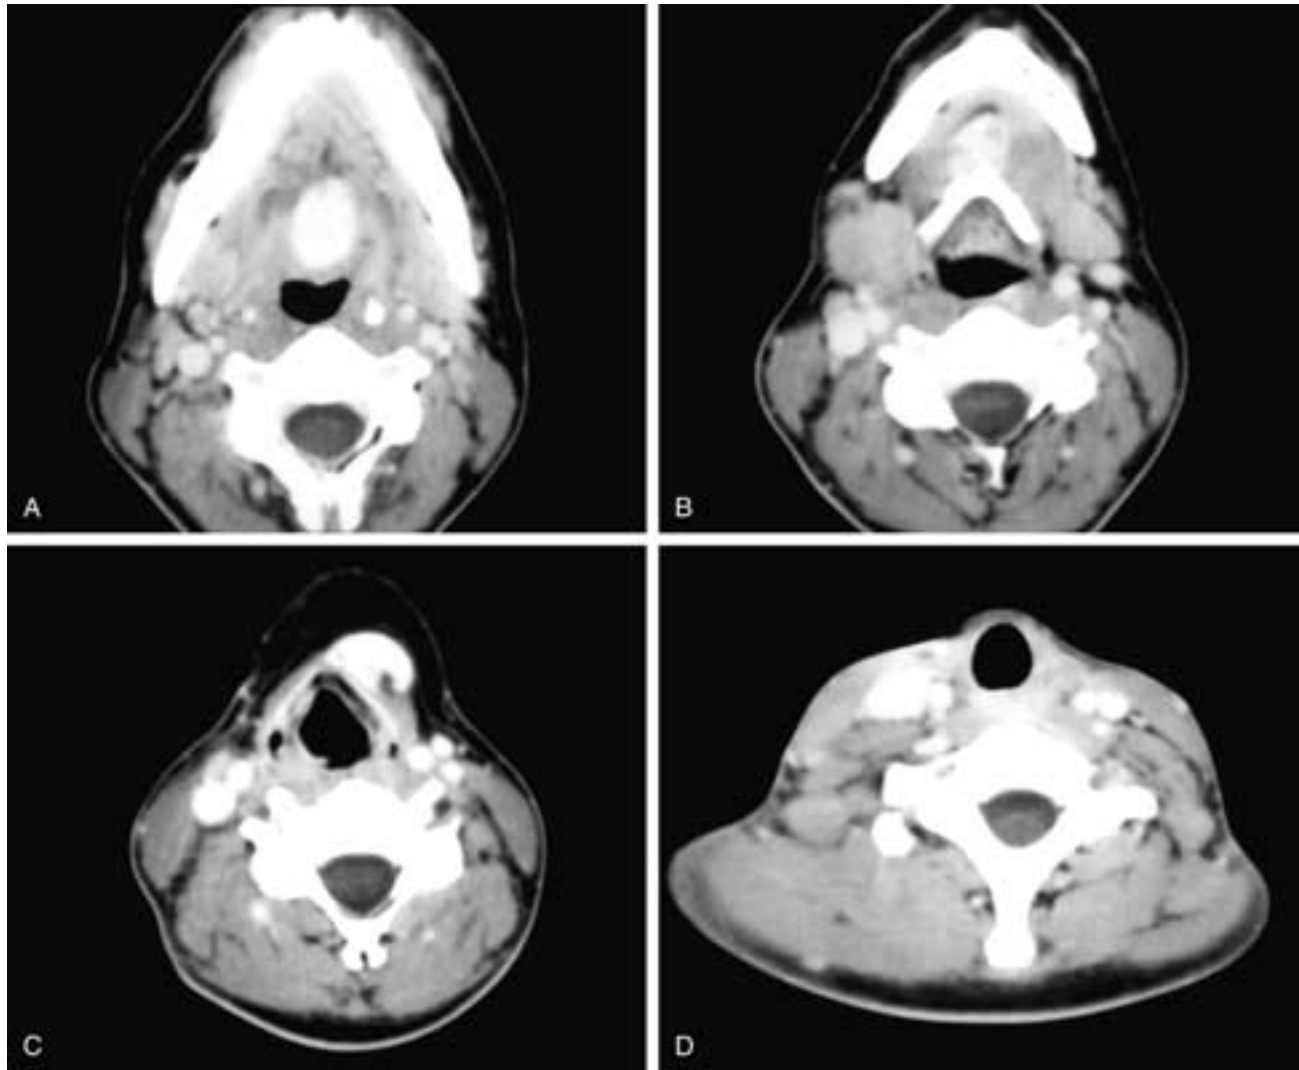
Serial axial contrast-enhanced CT scans from cranial (A) to caudal (D). In A, an enhancing mass is seen in the midline of the tongue. This was lingual thyroid tissue. In B, similar tissue is seen in the midline at the level of the hyoid bone. In C, similar tissue is seen adjacent to the outer contour of the thyroid cartilage and partially deep to the strap muscles. In all of these cases this was ectopic thyroid tissue, paralleling the location of the thyroglossal duct cysts in [Figures 35-14](#) to [35-21](#). In D, there was no thyroid tissue in the normal location of the thyroid bed. This occurs in about 80% of patients with lingual thyroid tissue.
